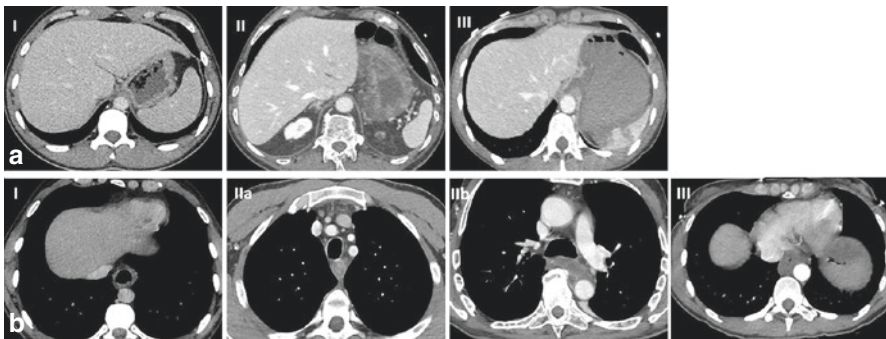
Computed tomography classification of caustic injuries of the stomach (a) and the esophagus (b)
